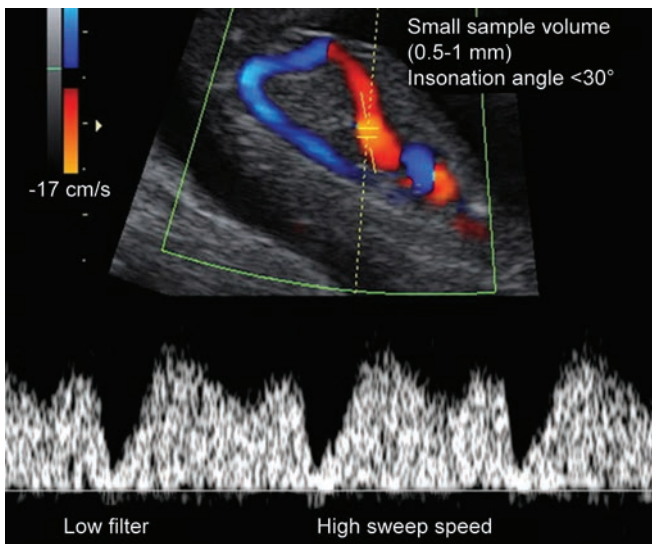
Doppler analysis of venous blood flow
